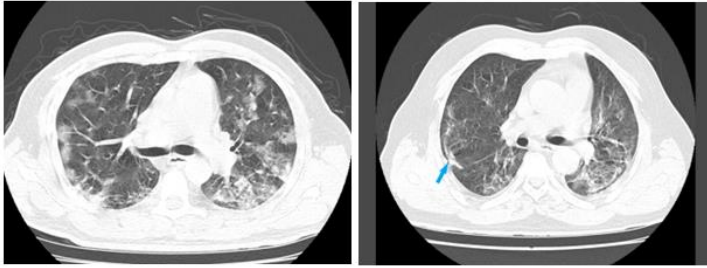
Axial HRCT upper lobe. image of the lung of a 32 yr old male patient showing crazy paving pattern (blue arrow) in the anterior segment of the left
